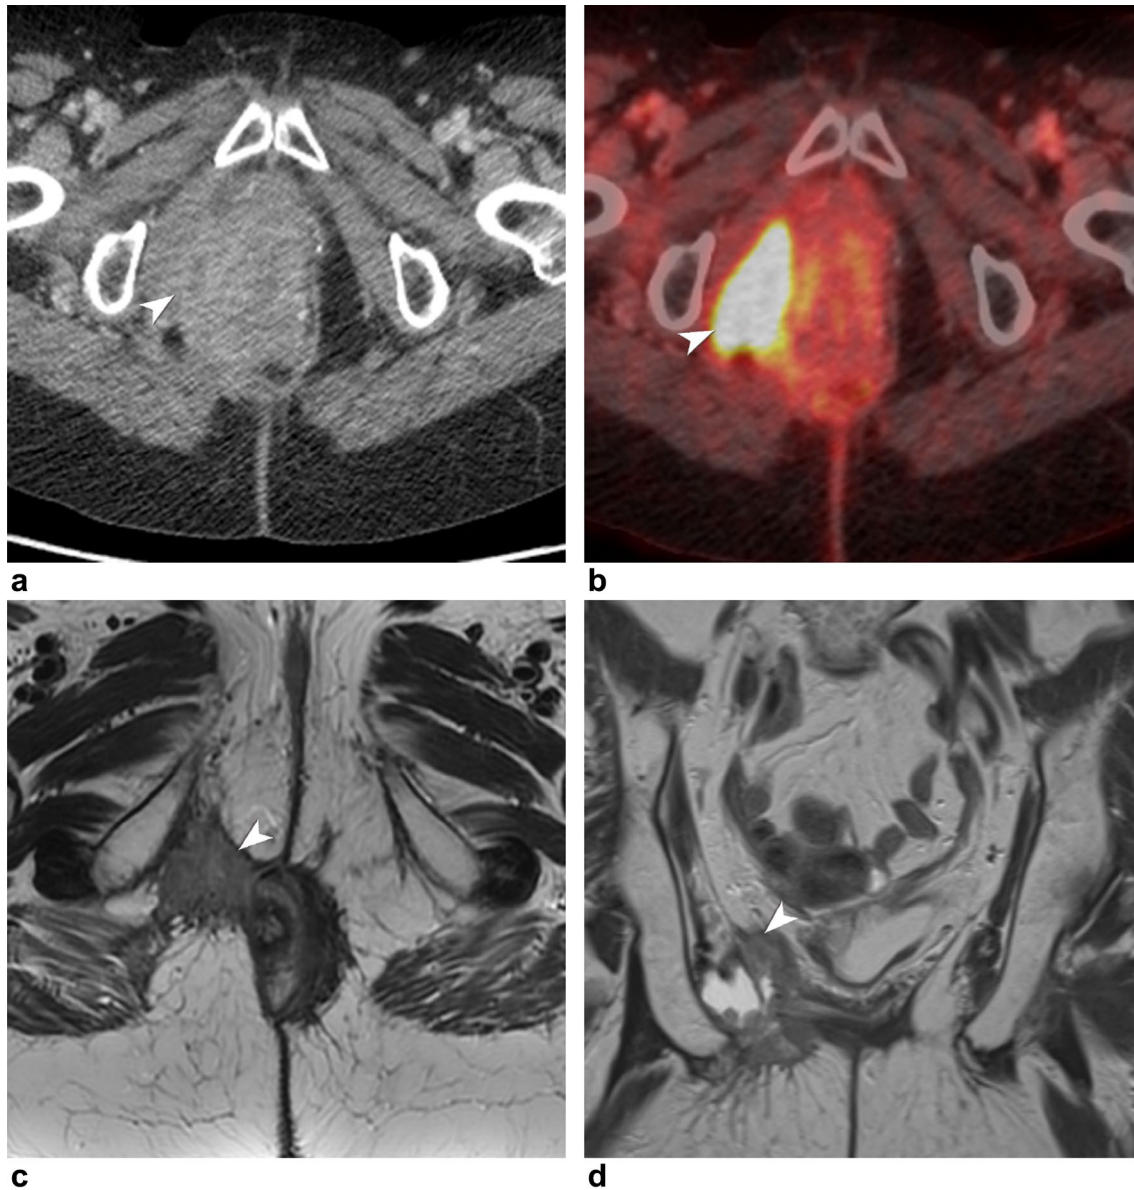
76-year-old male with anal squamous cell carcinoma, status post abdominoperineal resection, presents for surveillance. a Axial post-contrast CT image of the pelvis showing a soft tissue area with enhancement (white arrowhead) within the right ischiorectal fossa. b Axial PET/CT image of the pelvis shows the mass with high FDG
